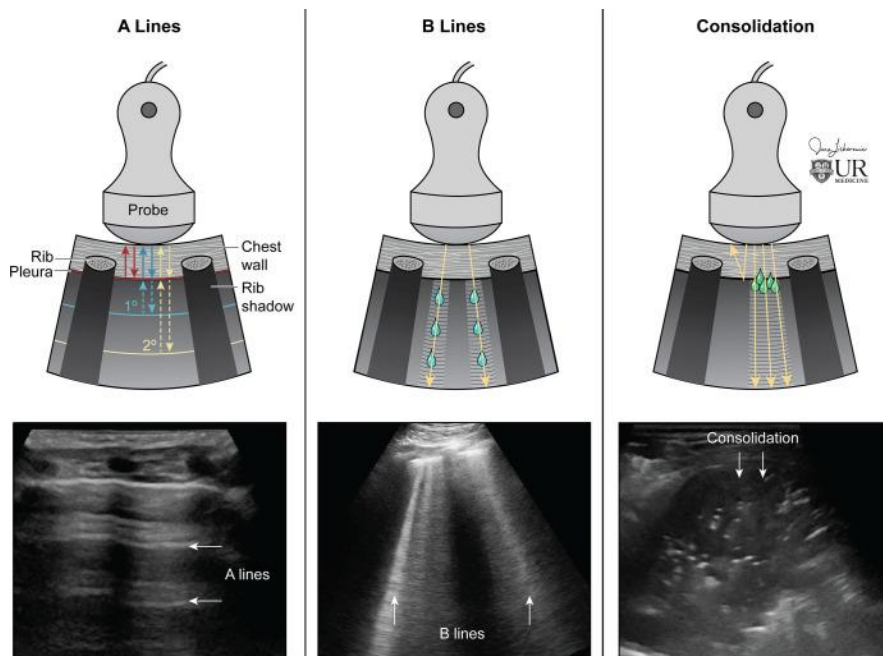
Ultrasound findings in different conditions affecting the lung (30)
